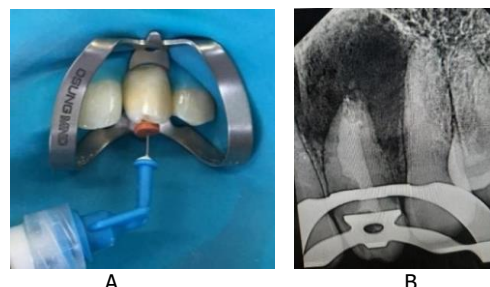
A. $\text{Ca}(\text{OH})_2$ dressing application; B. Radiography of $\text{Ca}(\text{OH})_2$ dressing application
